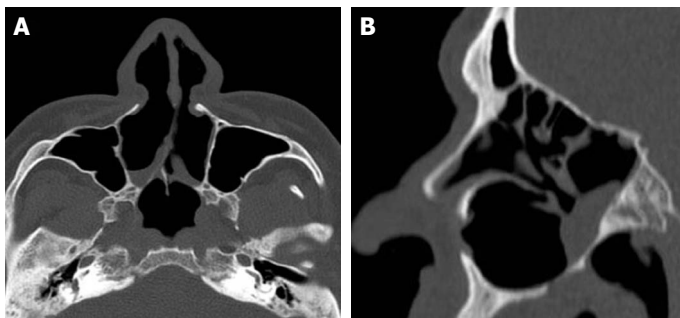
Bilateral choanal atresia is seen in computed tomography of the paranasal sinuses. (A) Axial section. (B) Sagittal section.
